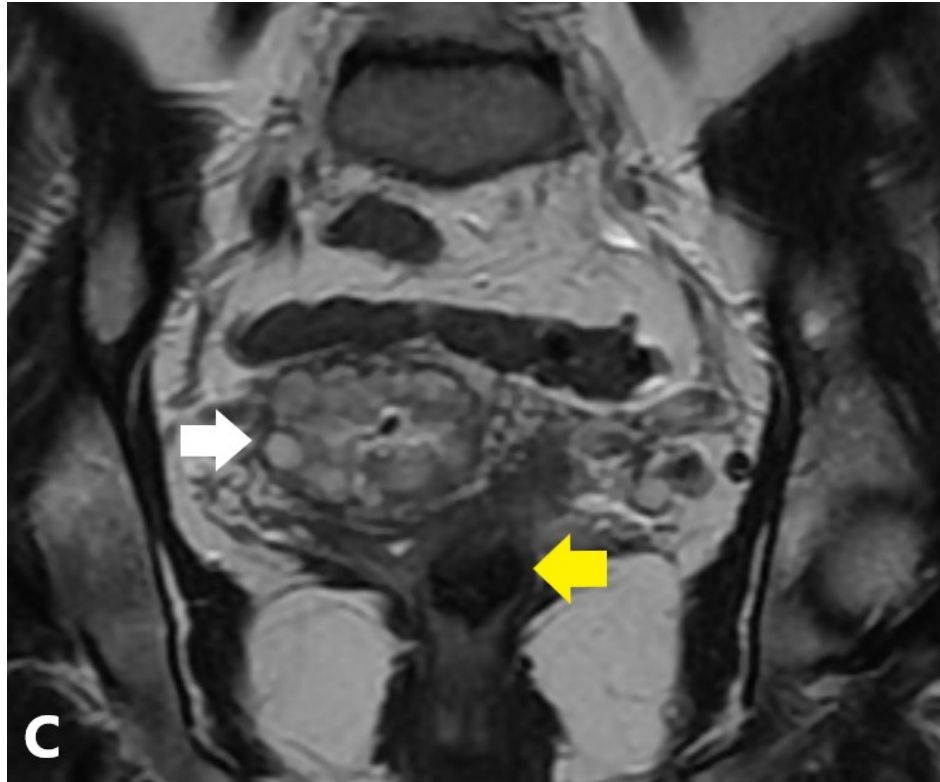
On a coned down T2-weighted fat saturated axial sequence of the pelvis, the cervix demonstrates numerous hyperintense cystic lesions within an enlarged cervix (solid white arrow). There is also a hypointense mass seen at the sigmoid colon (solid yellow arrow). B. On coronal STIR sequence of the pelvis, the cystic lesions demonstrates hyperintense signals with enlargement of the cervix. The cysts are seen extending deep into the cervical stroma with an associated solid component. C. Coronal T2-weighted fast relaxation fast spin echo sequence (FRFSE) sequence demonstrates mixed solid and cystic cervical lesion (solid white arrow).
